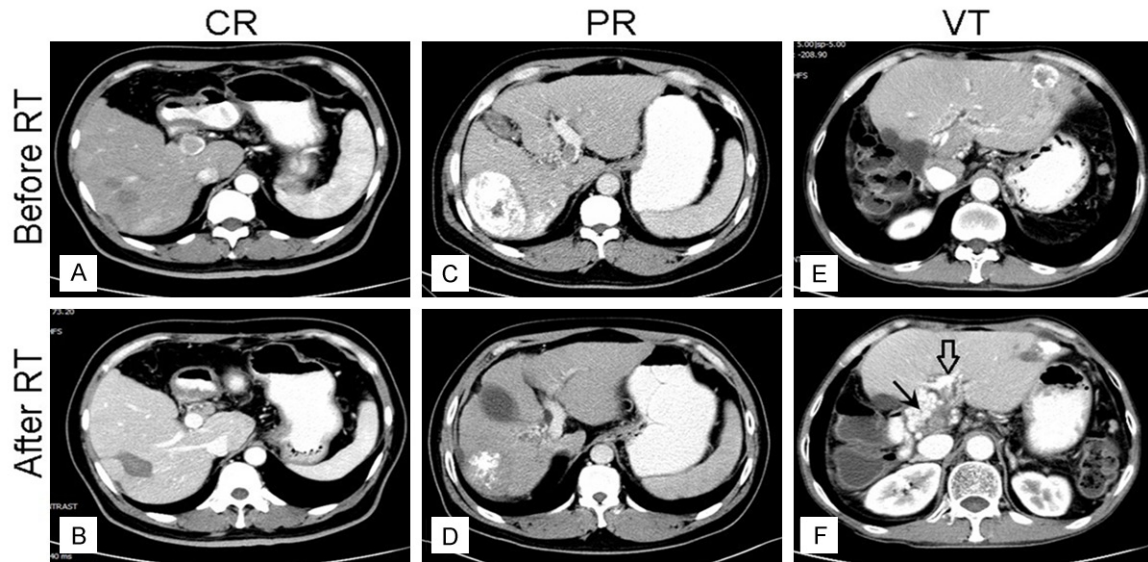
Serial computed tomography scans showed changes in images of the tumor thrombus area. A, B. There was a PVTT in the main trunk of portal vein. The thrombus completely disappeared after radiotherapy, and complete response (CR) was achieved. C, D. Tumor thrombus involved the right branch and the main trunk of portal vein, and the thrombus regressed after radiotherapy, partial response (PR) was achieved. E, F. The obvious cavernous transformation after radiotherapy (black arrow) was observed, which was classified as vascular transformation (VT) together with the partial recanalization (black hollow arrow) of portal vein.
